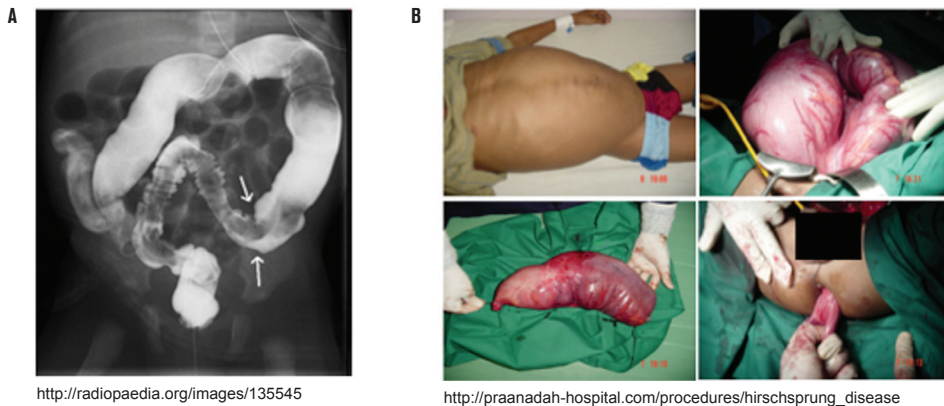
A) Barium enema X-ray of HSCR patient's bowel, the arrows shows the beginning of the aganglionic region. B) Treatment of HSCR patient with pull-through surgery to remove the aganglionic region and rejoin the healthy ganglionated colon to the anus.
